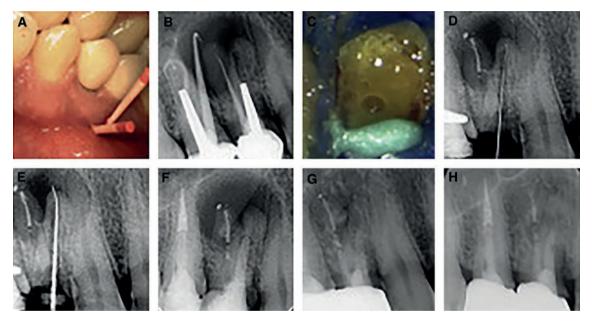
(A) Fistulas. (B) Fistulography. (C) Leaking of pus after crown and post removal. (D-E) Ledge management using manual files. (F) Filling of the perforation and root canal by biodentine. (G) 18 months radiographic follow-up. (H) 48 months radiographic follow-up.
